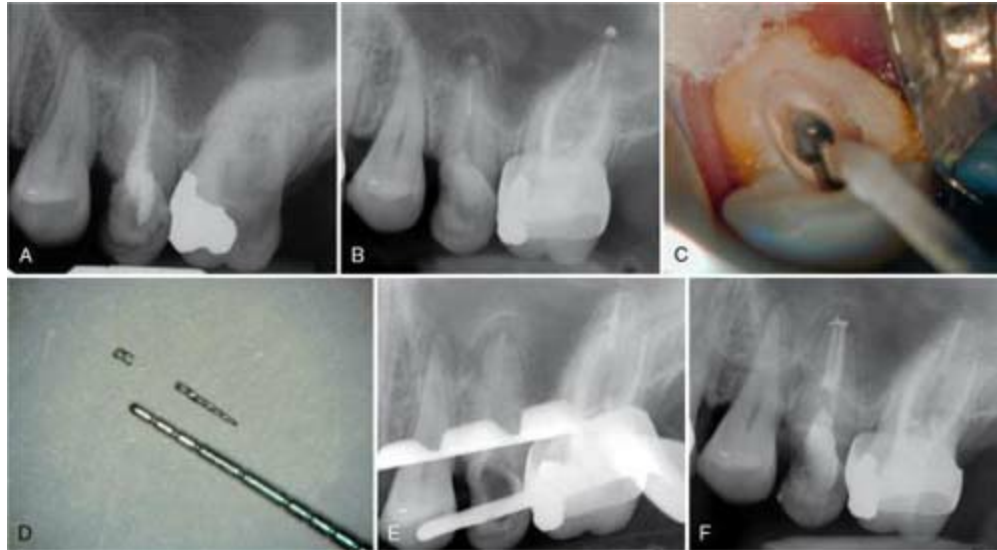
A, Preoperative radiograph showing a separated file in the palatal canal, potential coronal leakage, and apical periodontitis. B, Check film showing the separated instrument after gutta-percha removal. C, Photograph showing the separated instrument in the palatal canal and a paper point in the buccal canal to protect it. D, Separated nickel-titanium file removed. Note that it is in two pieces; a result typical when applying ultrasonic energy to nickel-titanium. E, Check film showing that the file has been completely removed. F, Final canal obturation.
